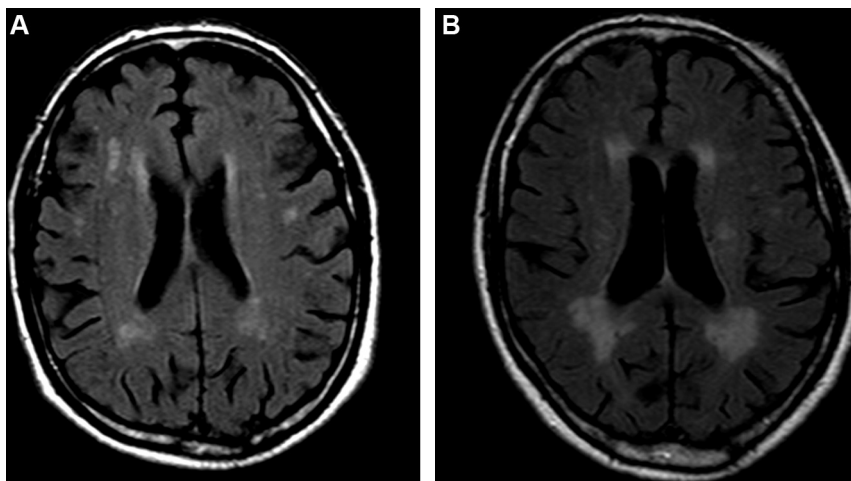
Male, 58 years old: FLAIR images showing WML in the periventricular white matter.
